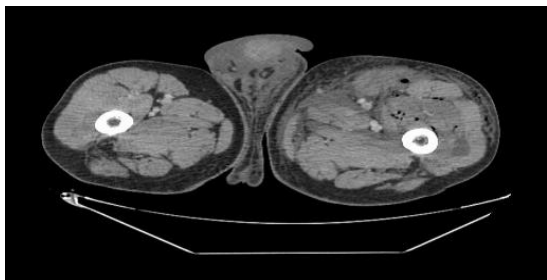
CT images - cross section with free gas: Upper thigh and scrotum.
